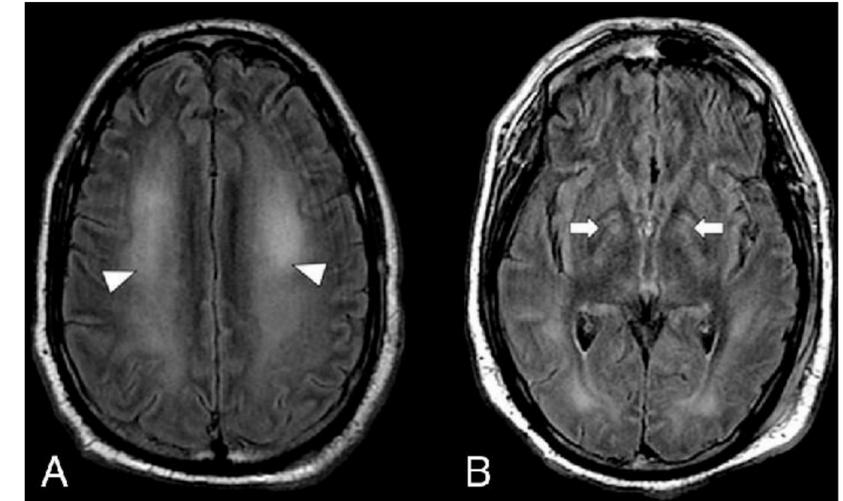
An axial MR imaging of the brain of 41-year-old man with COVID-19 and with persistent disorientation and decreased alertness 1 week after extubation. (A) A FLAIR image demonstrates hyperintensity throughout the cerebral white matter (arrowheads). (B) A more inferior FLAIR image demonstrates hyperintensity of the globi pallidi bilaterally (arrows).
